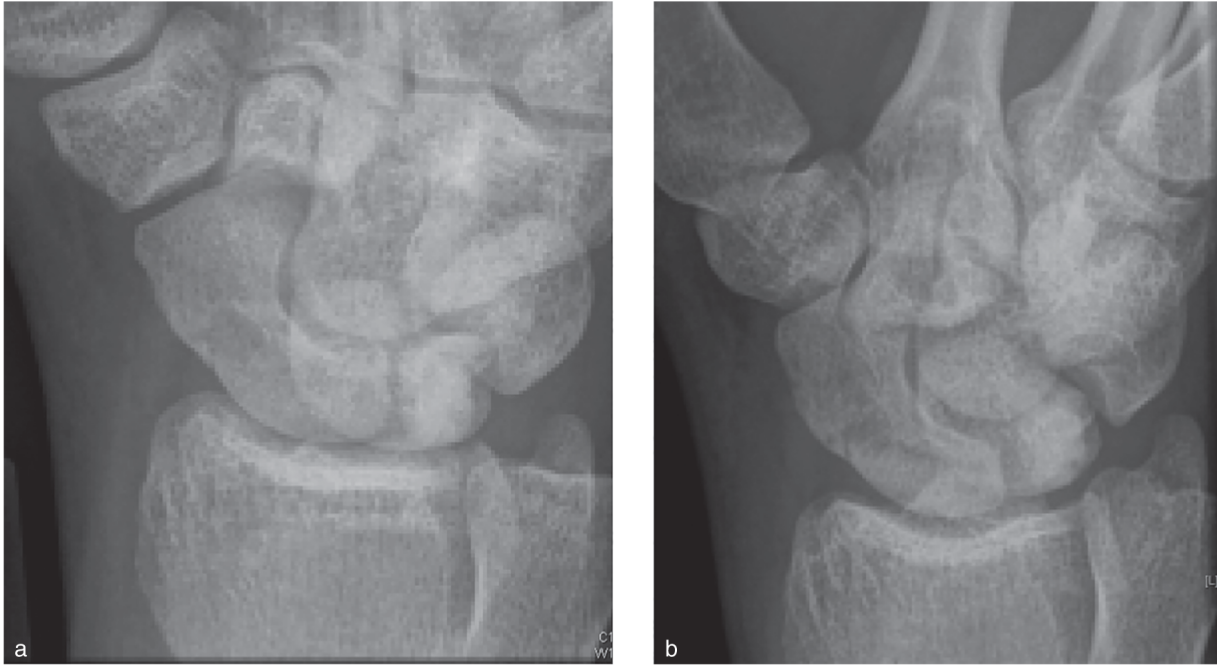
Pronated oblique view of the same patient in [Figure 89.1](#): (A) following the injury, there was a doubt about a waist fracture; (B) 10 days later, radiograph reveals more clearly the waist fracture.
